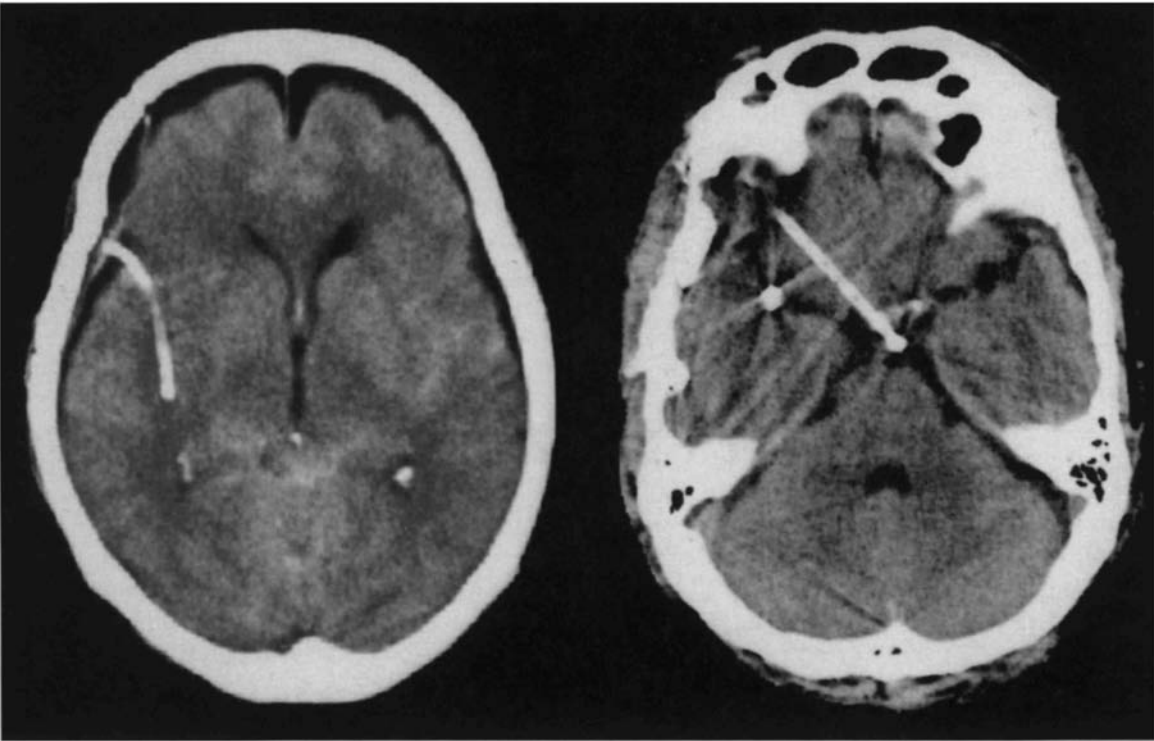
Computed tomographic scans showing the position of the irrigation tubes. The inlet tube is positioned
